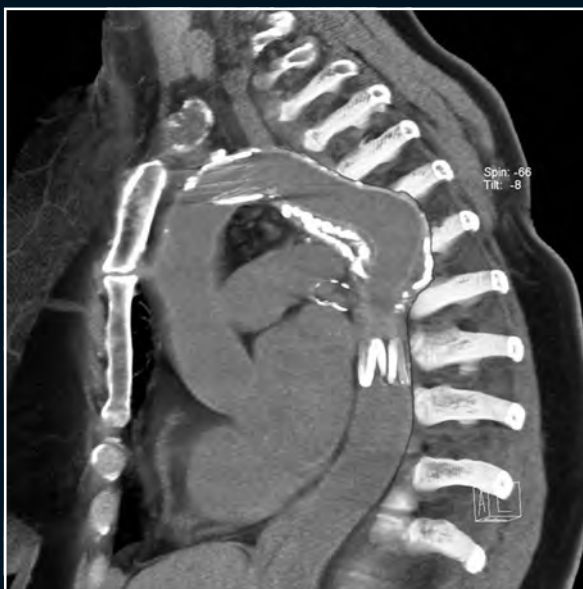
CT scan of patient K. 23 years after hybrid procedure.
